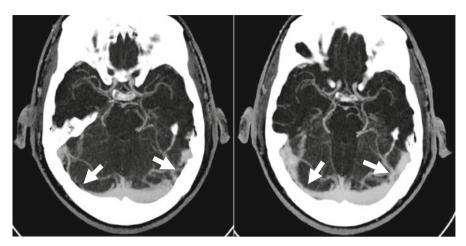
CT venogram in a case of PTCS with compressible veins: immediate effects on the transverse sinuses of CSF withdrawal by lumbar puncture. Courtesy of Dr. N. Higgins
